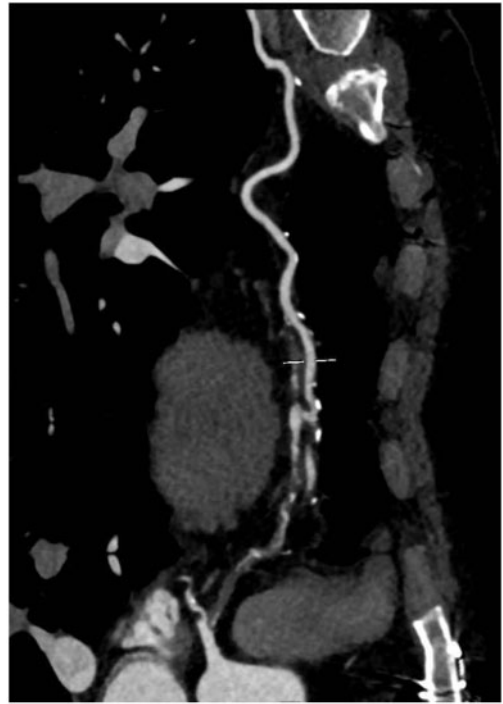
Curved multiplanar reconstruction on cardiac computed tomography with contrast 3 months after invasive coronary angiography showing resolution of the spontaneous dissection of the left internal mammary artery bypass graft.
